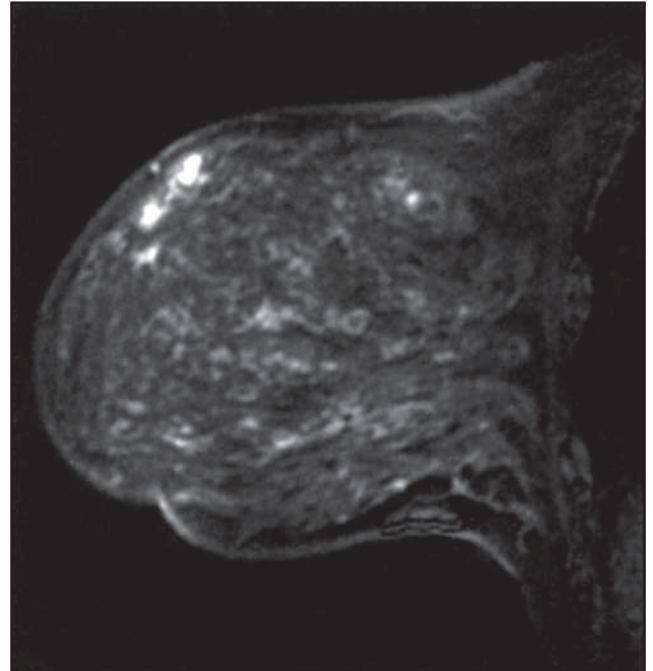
Screening breast magnetic resonance (MR) image of a 49-year-old woman at high-risk for breast cancer. Sagittal T1-weighted contrast-enhanced MR of right breast shows focal-clumped enhancement superiorly. MR-guided needle localization and surgical excision yielded invasive lobular cancer (0.7 cm). (Reprinted with permission from: Bartella L, Liberman L, Morris EA, Dershaw DD. Nonpalpable mammographically occult invasive breast cancers detected by MRI. *AJR Am J Roentgenol.* 2006;186:866.)
